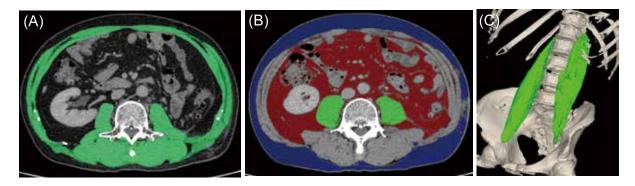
Three-dimensional reconstruction of computed tomography scanning images by Vincent version 4. (A) Skeletal muscle index (SMI) at the third lumbar vertebra (L3). (B) Psoas muscle index (PMI), subcutaneous fat area (SFA), and visceral fat area (VFA) at L3. (C) Psoas muscle volume (PMV).
